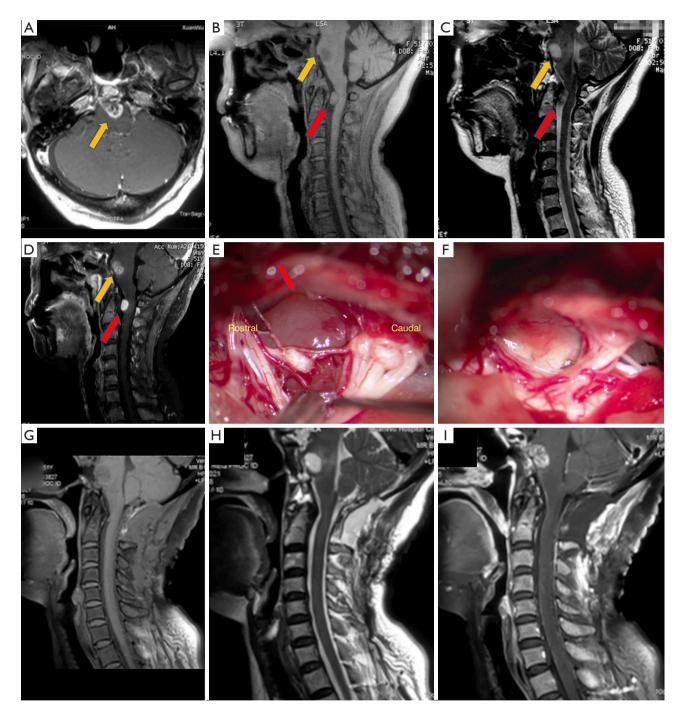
Follow-up MRI of the clival chordoma recurrence *in situ* and new lesion at C1 to C2 level 16 months after endoscopic surgery. (A-D) MRI showed growth of the recurrent lesion *in situ* (the yellow arrow) and a new lesion in the spinal canal at C1 to C2 level (the red arrow). (E) Intraoperative conditions of the intraspinal lesion (the red arrow). (F) The lesion was completely resected. (G-I) Six months follow-up MRI showed the intraspinal lesion was totally removed. MRI, magnetic resonance imaging.
